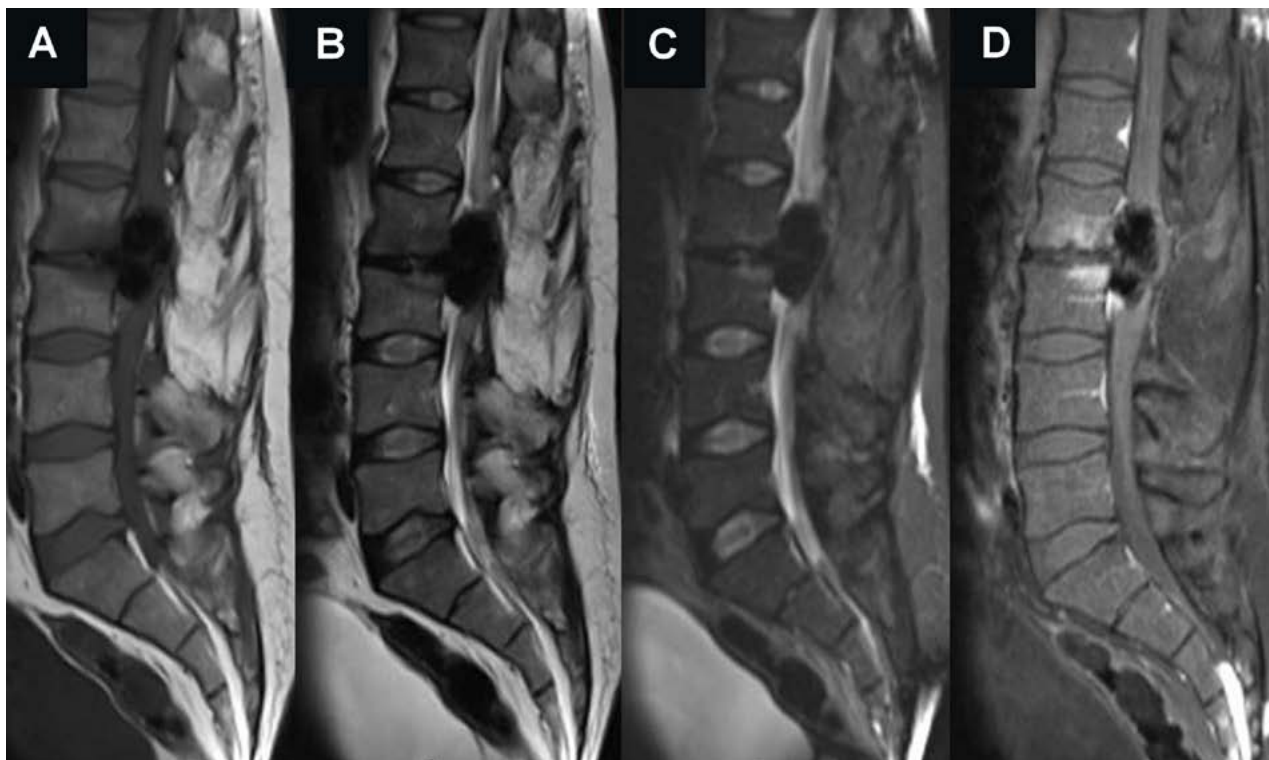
MRI of the lumbar spine showing a material characterized with a hypointense signal on all weighted sequences at T1 (A), T2 (B), and STIR (C), with a slight highlight of surrounding tissues in T1 after the administration of intravenous contrast medium, in addition to a strong compression effect on the conus medullaris.
